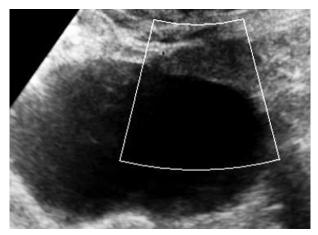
Transabdominal ultrasound of case #7
